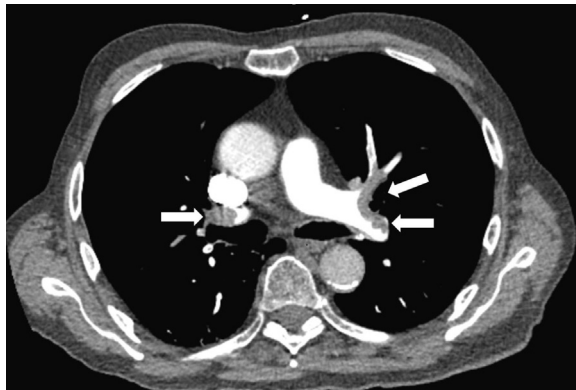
Pulmonary emboli (white arrows) on CT. (Original: 251 × 169 mm [120 × 120 DPI].)
